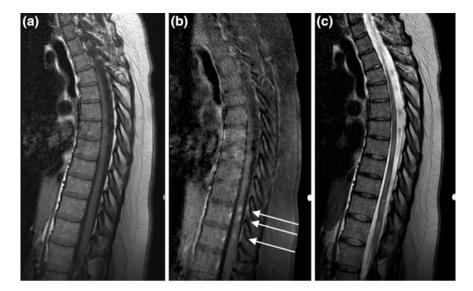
T1 sagittal images of the lumbar spine before and after contrast enhancement. Sagittal plane images from an MRI study of the spine demonstrating pathologic enhancement and so increased conspicuity of multiple sclerosis lesions (*arrows*) in the spinal cord of a 52 year old patient. Images obtained include a T1, b T1 post intravascular contrast administration, and c T2 images
